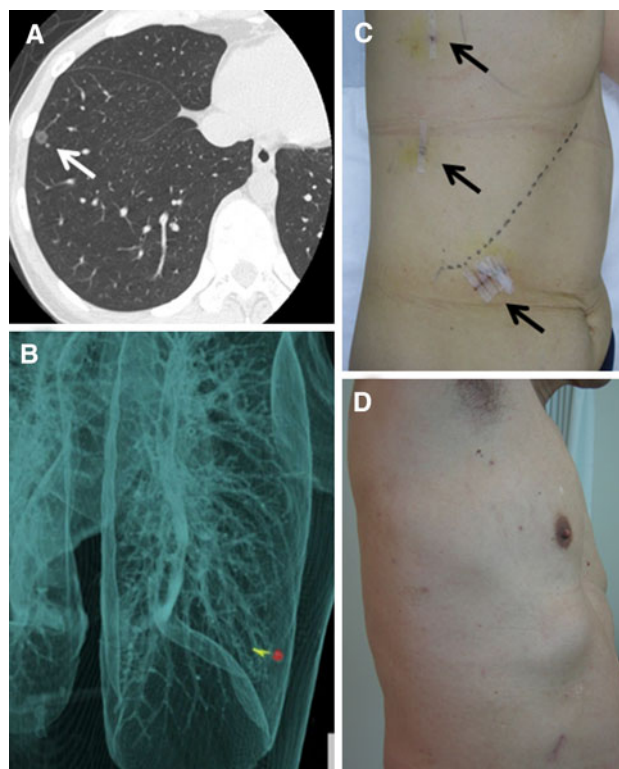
A Preoperative chest computed tomography (CT) scan of a 36-year-old woman showing a tiny ground glass opacity nodule (arrow) in S8 of the right lung. B Three-dimensional X-ray of a 36-year-old woman after percutaneous pulmonary marking of the nodule under CT guidance. C Skin wounds of a 36-year-old woman on postoperative day 7 indicating two 3-mm puncture wounds and one 2-cm subcostal wound. D Skin wounds of a 66-year-old man 2 months after the operation. The patient had diffuse pleural adhesions, and three 3-mm ports were placed in addition to the standard ports. It is difficult to identify the five 3-mm puncture wounds on the thorax in this image
